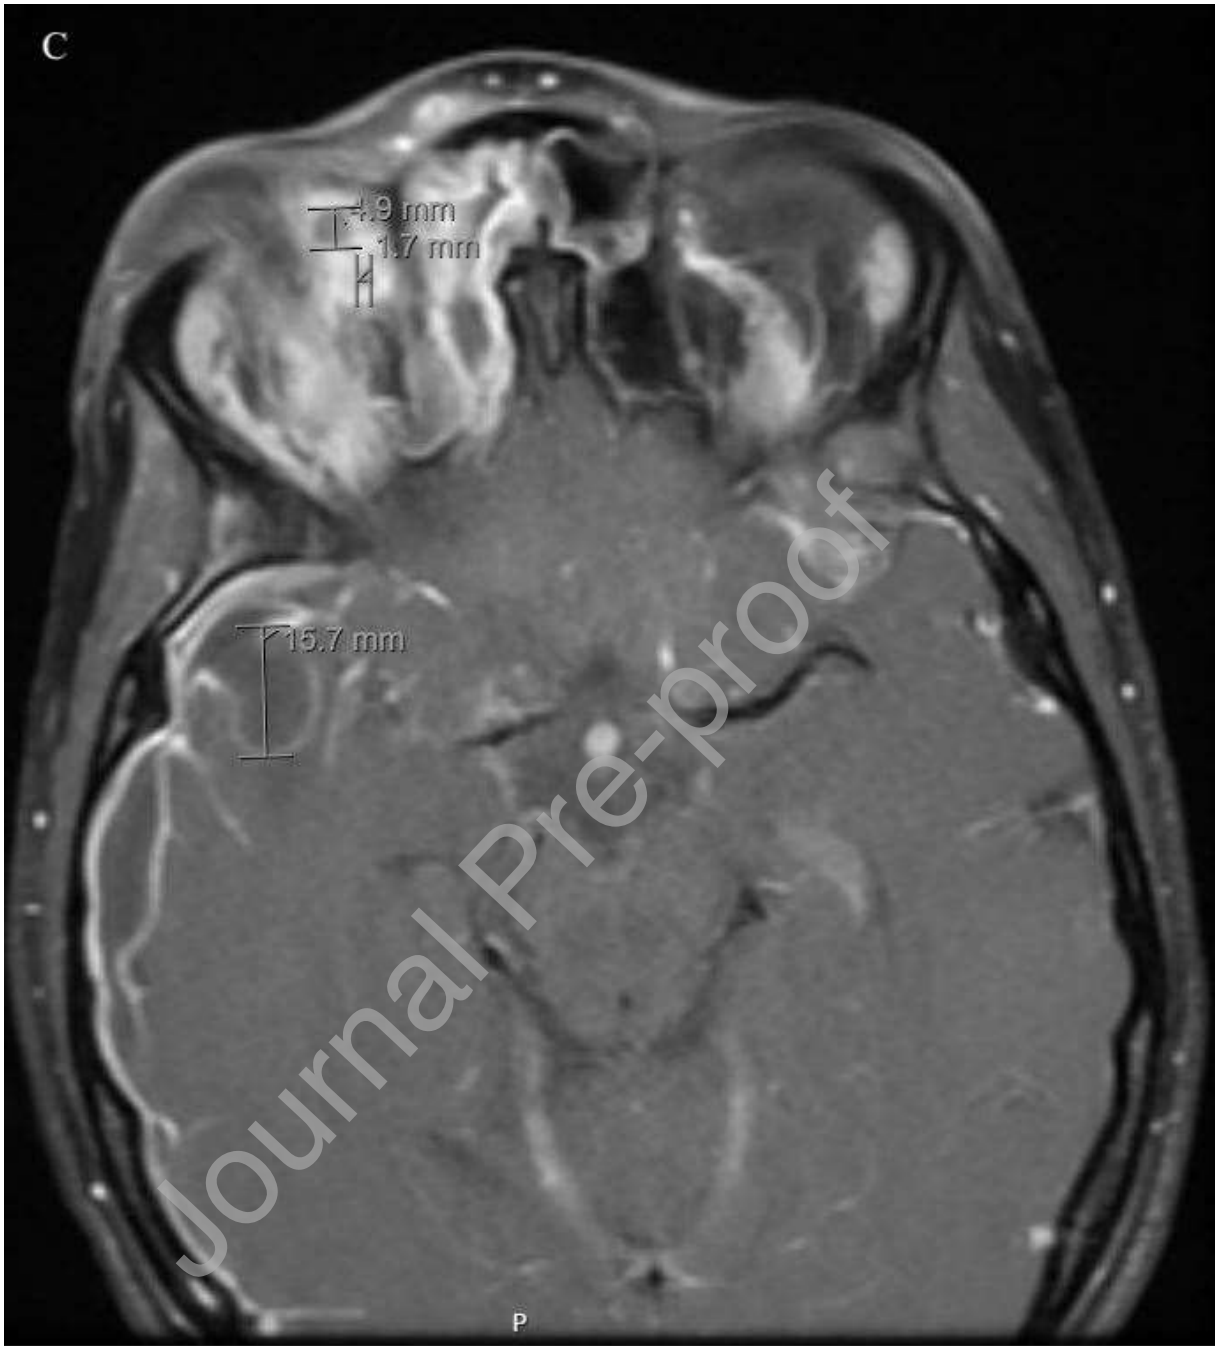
MRI showing (A) IJ thrombosis (arrow), proptosis, and abnormal enhancement of the right periorbital soft tissue, (B) distention of the right superior ophthalmic vein and lack of IV contrast enhancement (arrows) consistent with thrombosis. There is additional cavernous sinus and sigmoid sinus thrombosis, (C) abscesses within the right posterior orbit and right temporal lobe, (D) right temporal lobe abscess, right subdural empyema, bilateral cavernous sinus thrombosis, and small left temporal lobe abscess.
